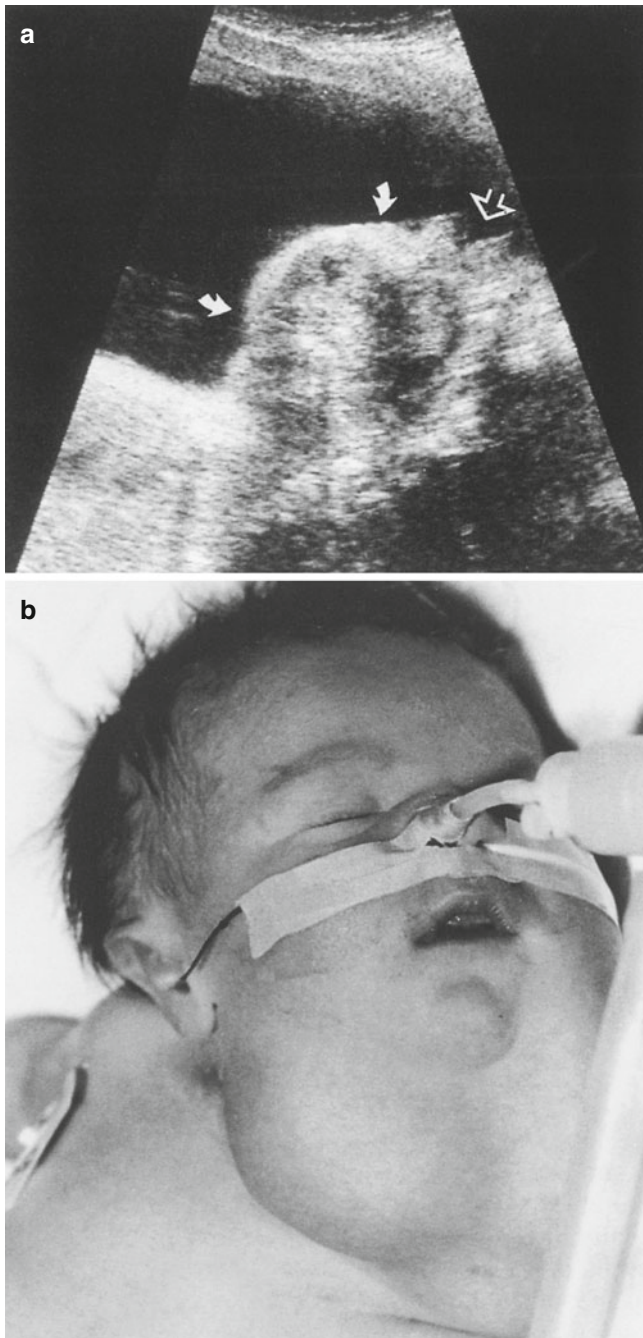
(a) Antenatal ultrasound of a cervical teratoma (b) Infant with a cervical teratoma causing respiratory distress
